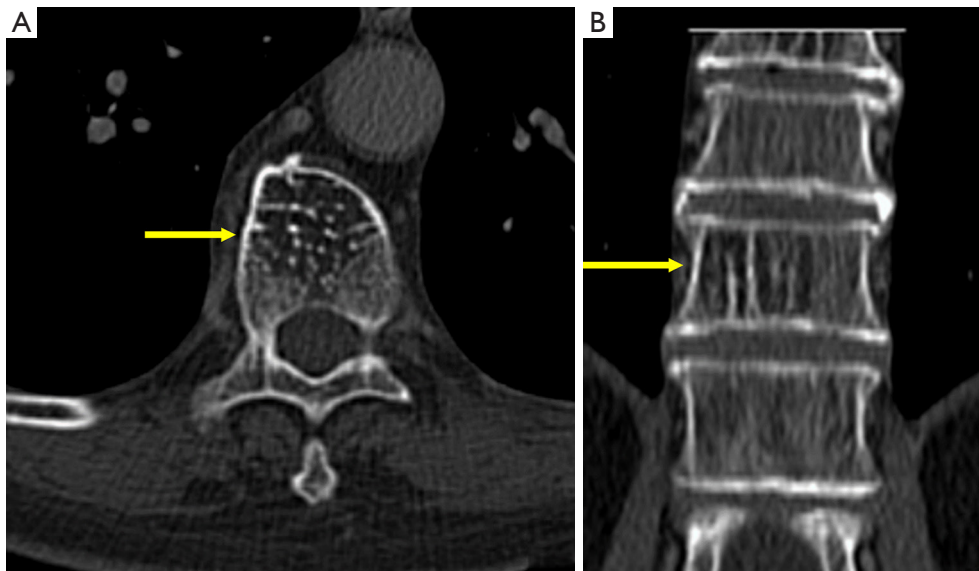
A patient with the typical appearance of a vertebral hemangioma. (A) Axial CT imaging demonstrating corduroy or polka-dot appearance in the vertebral body (arrow). (B) Coronal CT imaging demonstrating a coarse, vertical trabecular pattern lesion (arrow) in the vertebral body, consistent with a vertebral hemangioma. CT, computed tomography.
